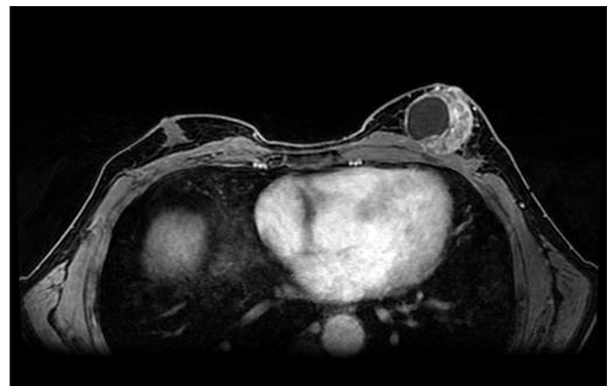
Invasive cribriform carcinoma on MRI. Contrast-enhanced T1-weighted MRI shows a circumscribed mass with a cystic area and heterogeneous enhancement of the solid portion. The mass is closely attached to the pectoralis muscle.
